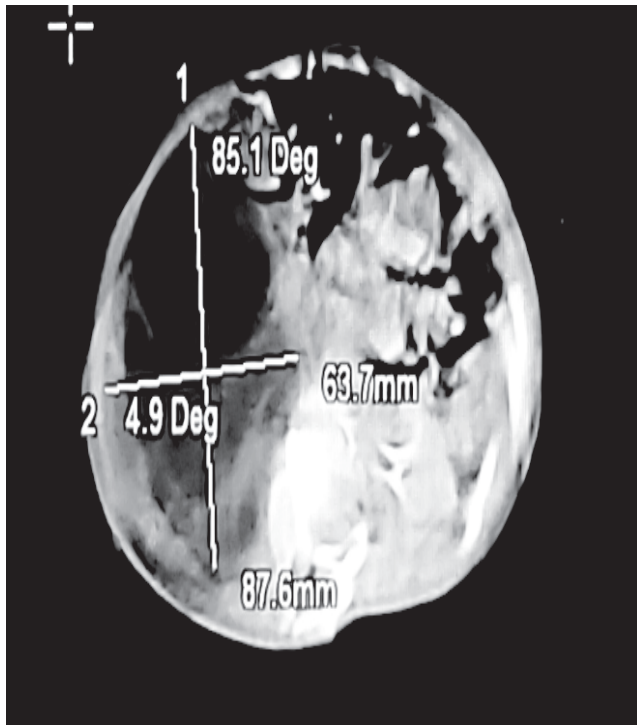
Axial contrast CT scan of abdomen showing large fat containing right renal mass compressing adjacent abdominal structures, no perilesional fat stranding or extension along right renal vein and minimal collection in anterior aspect of right kidney.
